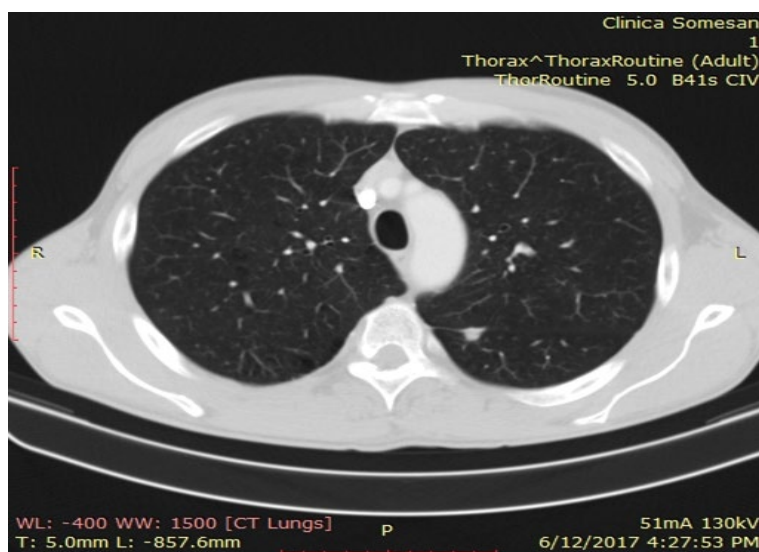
CT scan: a 7 mm nodule in the superior segment of the LLL
